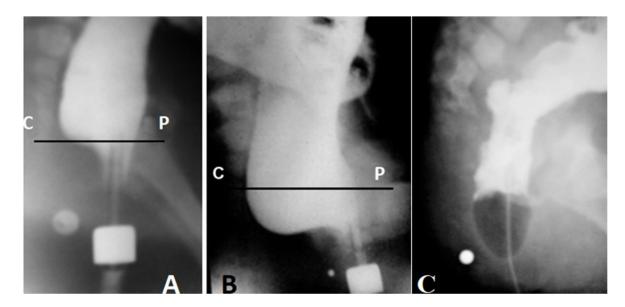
Lateral radiographs of the anorectum made in the same girl with vestibular fistula at a different age. P-C is the pubococcygeal line. The true diameter of the contrast marker, strung on the tip of the enema is 1.6 cm. It is located near the fistula orifice. (A). At the age of 8 months. Permanent contraction of the ectopic anal canal was observed during the barium enema. Its length is 2.5 cm, which corresponds to the anal canal age norm. The width of the rectum is 3.4 cm, which is greater than the maximum normal limit (3 cm) (megarectum). Barium penetrates the anal canal behind the tip of the enema. This shows the weakness of the PRM, which is not pulls of the posterior wall forward. (B). At the age of 1.5 years she had a severe constipation and soiling. The width of the rectum is 5.5 cm, which significantly exceeds the maximum limit of the norm for this age (3.7 cm). A megarectum is combined with significant shortening of the anal canal. Its length is 1.9 cm (minimal limit is 2.3 cm). Conclusion. ARM with vestibular ectopy, megarectum and descending perineum syndrome. (C). After emptying the gut, the Foley catheter was inserted into the rectum. After inflating the balloon, the catheter is retracted down
